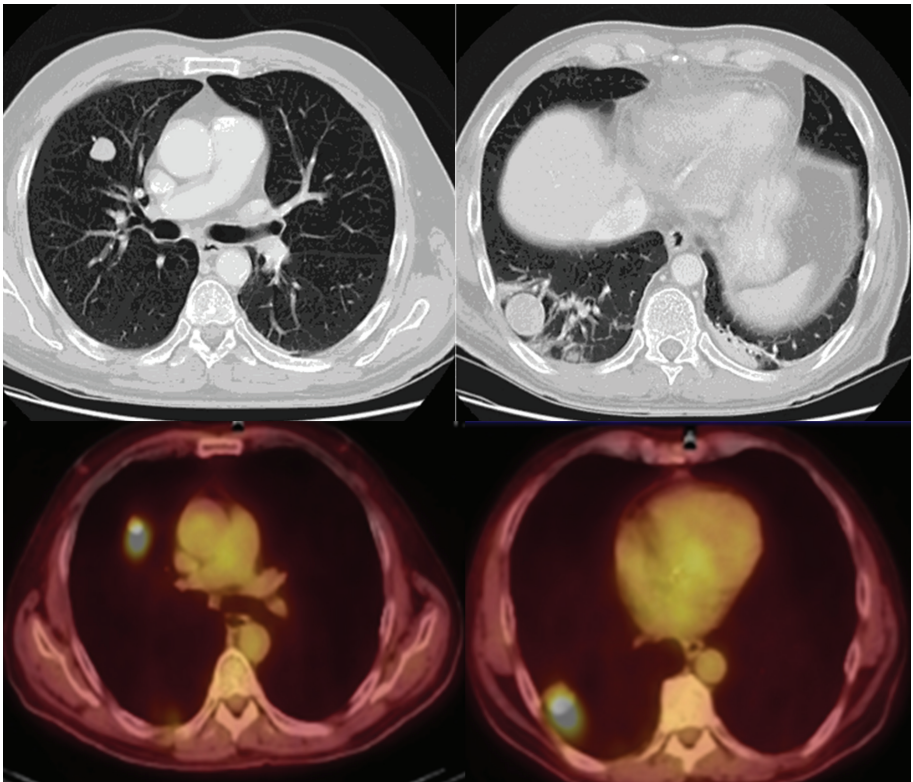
Pulmonary nodules. FDG PET/CT demonstrates hypermetabolic activity within two right lung pulmonary nodules. This patient was status post left testicular mass resection revealing a nonseminomatous germ cell tumor with pathologic staging of pT4 Nx Mx. Findings on PET/CT were consistent with pulmonary metastases resulting in final staging of T4 N0 M1.
